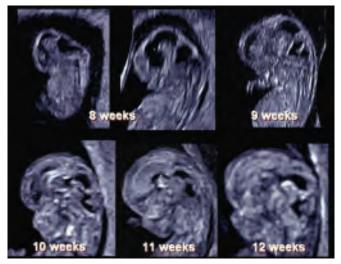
Normal brain development by midsagittal threedimensional ultrasound (3D US) section between 8 and 12 weeks of gestation
